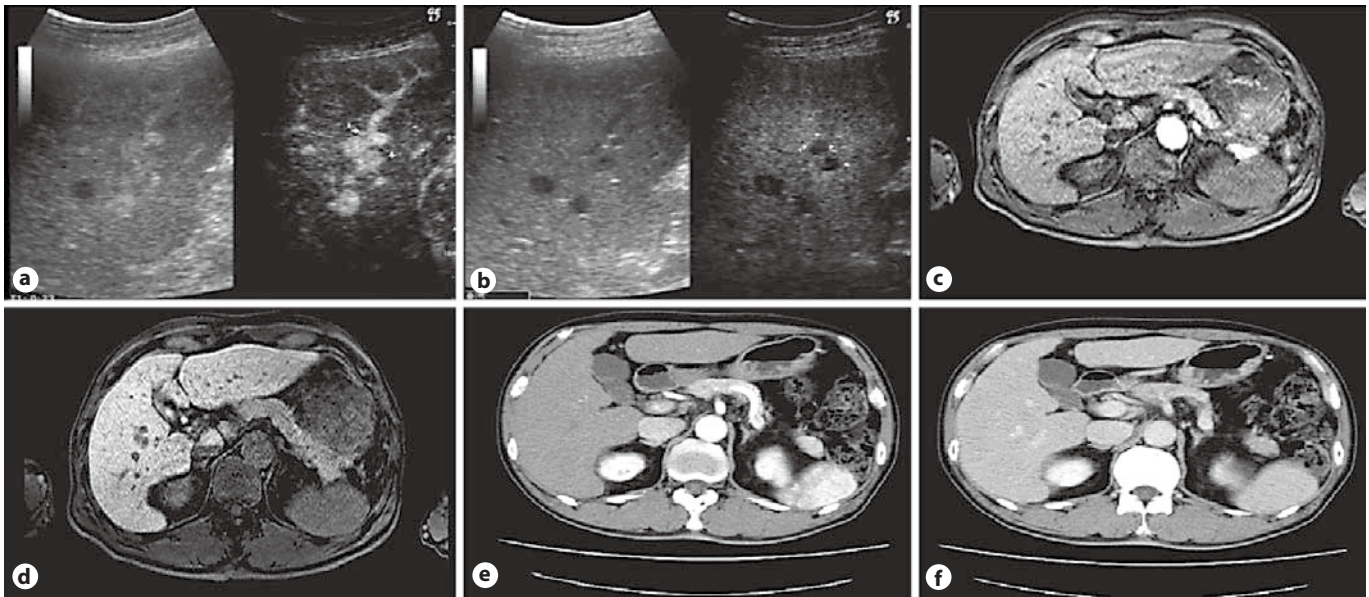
Detection by Sonazoid-enhanced US and Gd-EOB-DTPA-MRI. a Sonazoid-enhanced US revealed hypervascularity in the early vascular phase. b A defect in the Kupffer phase. c No hypervascularity in the arterial phase of Gd-EOB-DTPA MRI. d A defect in the hepatobiliary phase. e CECT could not reveal hypervascularity in the arterial phase. f No washout in the portal phase.
